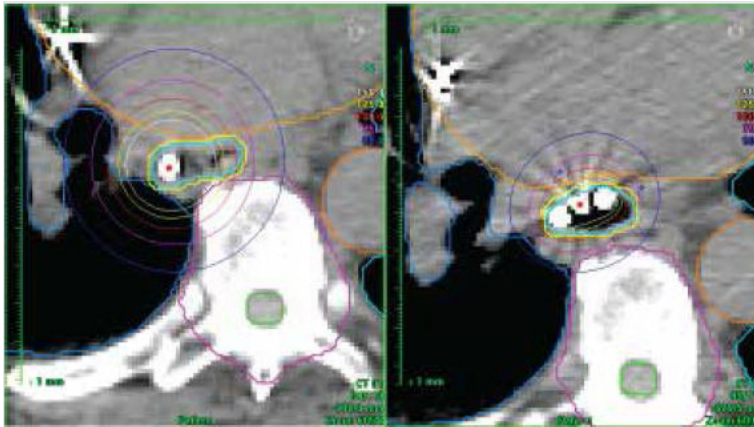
Axial CT treatment planning images for two patients undergoing HDR brachytherapy. Image on the left demonstrates the isodose distribution in a patient treated with a single tube, patient on right was treated with 3-tube technique. Note that all of the circles (representing isodose lines) are smaller with the 3-tube technique.
